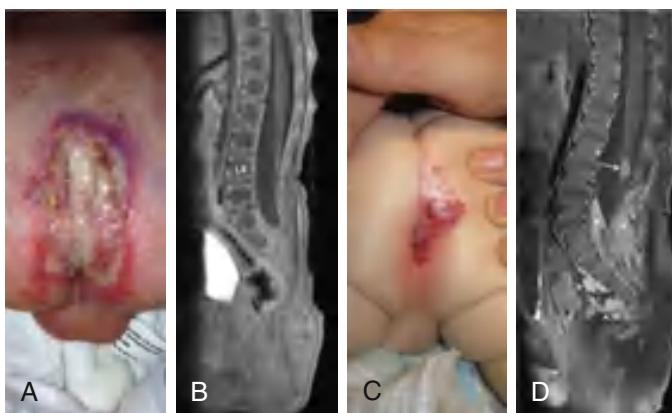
A, Lumbosacral ulcerative plaque with surrounding red vascular rim was noted on initial examination. B, Midline sagittal contrast-enhanced, T1-weighted, fat-saturated image of the lumbosacral spine at presentation reveals low-lying conus at the L4 vertebral level suggestive of tethered cord. C, Recurrence of lumbosacral hemangioma after discontinuation of oral propranolol. D, Midline sagittal contrast-enhanced, T1-weighted, fat-saturated image of the lumbosacral spine at 6 mo of age shows new nodular enhancing lesion at the lower end of the conus (arrow) compatible with intrathecal hemangioma. In addition, there is a large hemangioma in the epidural space in the sacral spinal canal (asterisks) with presacral extension (arrowheads). (From Yu J, Mapeshwari M, Foy AB, et al. Neonatal lumbosacral ulceration masking lumbosacral and intraspinal hemangiomas associated with occult spinal dysraphism. *J Pediatr*. 2016;175:211–215.)
